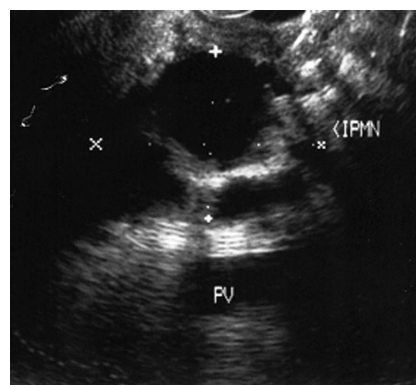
Endoscopic ultrasound image demonstrating an intraductal papillary-mucinous neoplasm.
